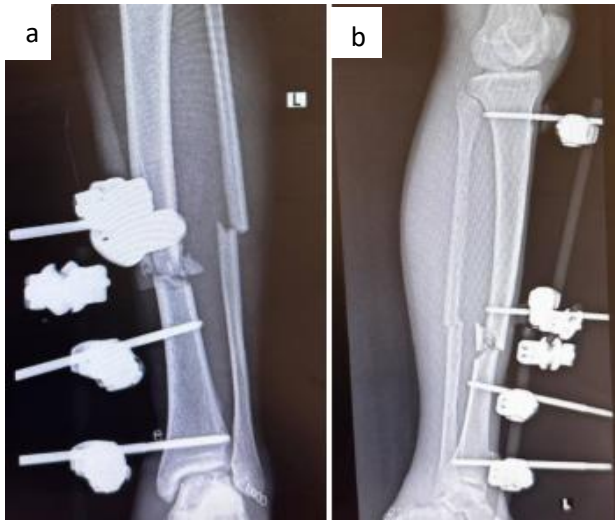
(a, b): Anteroposterior and lateral radiographs showing the external fixation of tibia.
